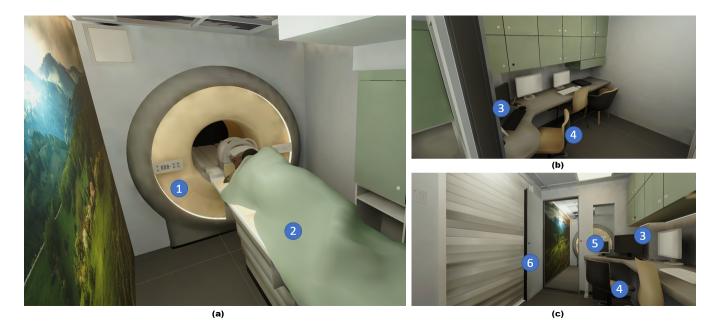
The indoors of a mobile MRI truck as seen by the VR headset wearer: (a1) the MRI device, (a2) the avatar of a patient undergoing an MRI scanning procedure, (b3), (c3) a monitor which will show MRI scan results, (b4), (c4) an avatar of a movable physical chair, (c5) button for starting MRI scan which will cause the doors (c6) to close, sliding of the avatar into the MRI device, and scan to start.
